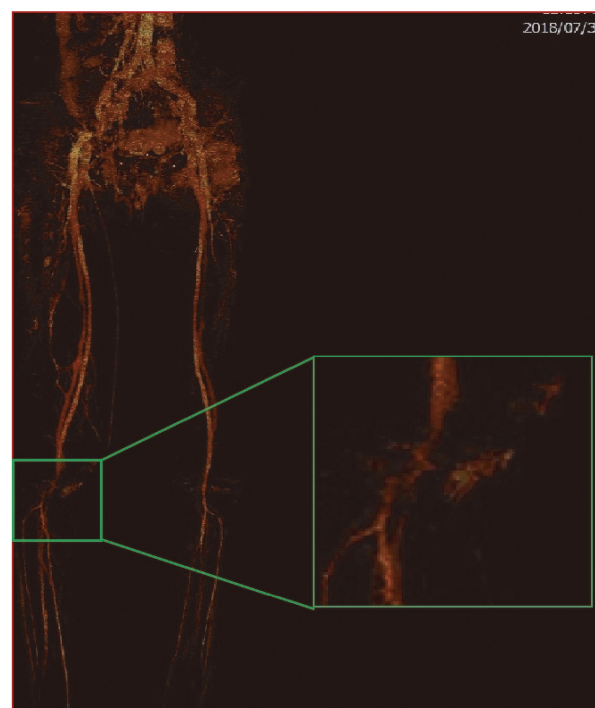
CTA features of atherosclerotic stenosis and thrombosis in lower extremity vessels.
